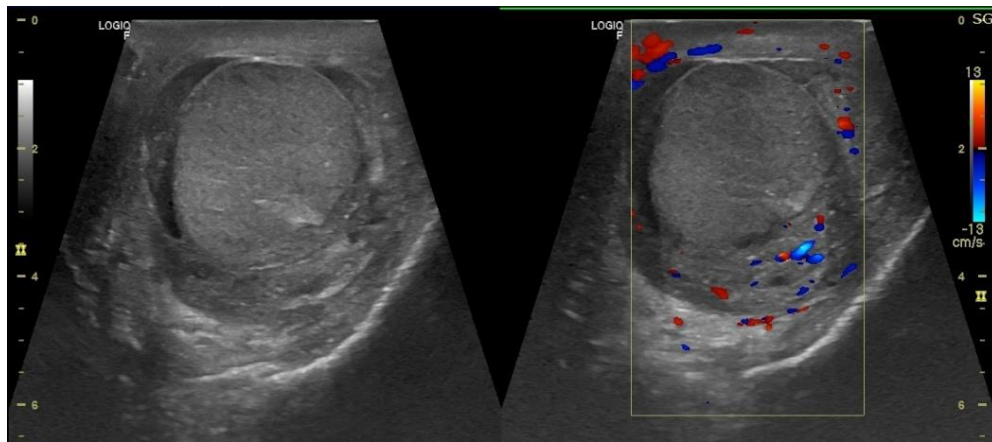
Ultrasound and color flow images of left testis. Grey scale image on left side and color Doppler on right side. The flow is seen on the peripheral part without any intratesticular flow.
